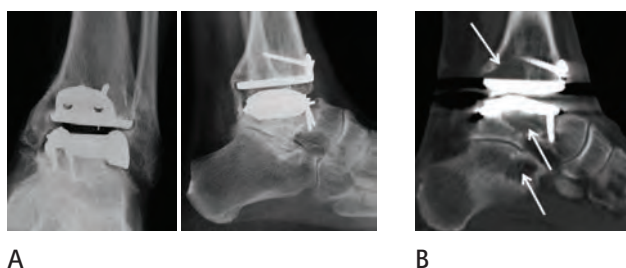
Periprosthetic cysts formation has become a major concern in total ankle replacement. They cannot always been recognized on conventional x-rays (A) and require a CT-scan to be quantified (B).
